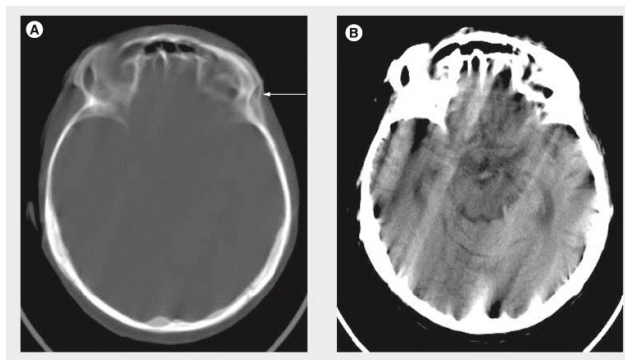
The effect of motion on the CT image. Motion can cause blurring or double images, as shown on the left side (A), or long streaks as shown on the right side (B) (2012).
